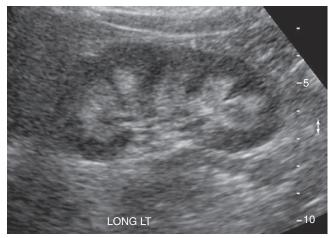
Sagittal sonogram of the left kidney.
